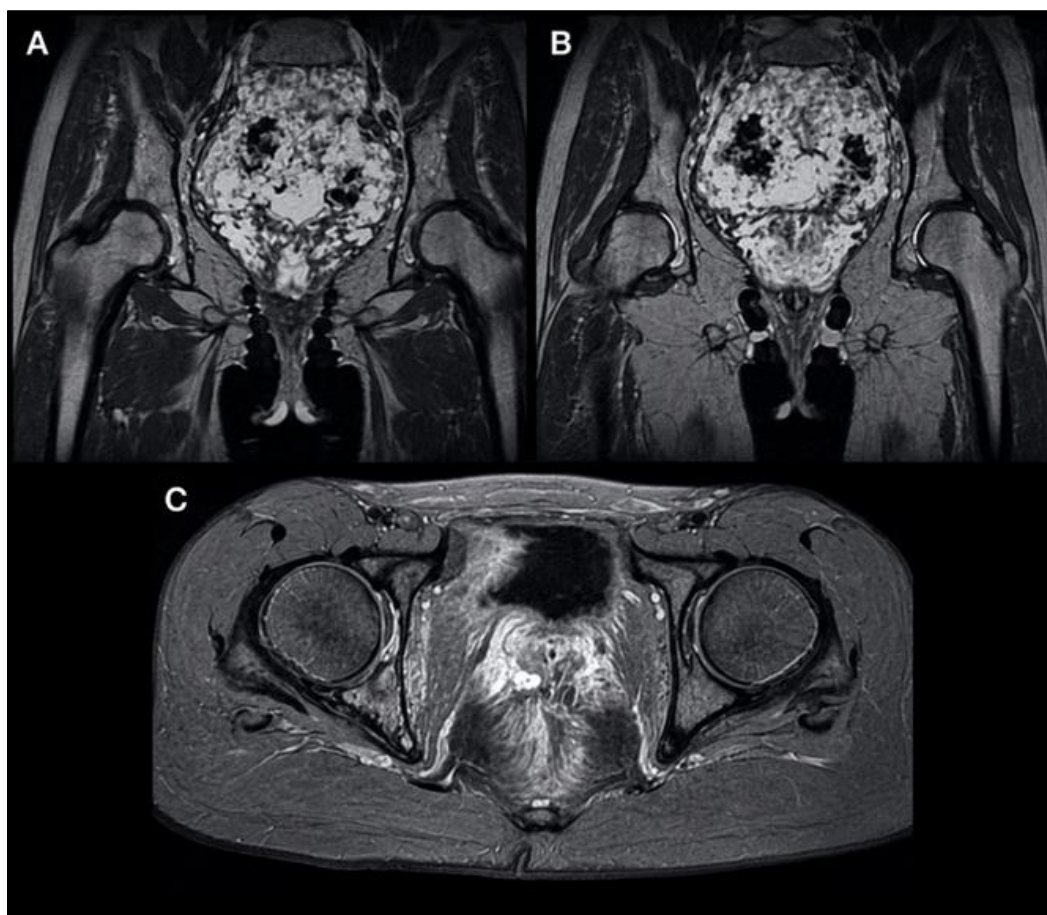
Post-neoadjuvant chemotherapy MRI demonstrating a marked reduction in tumor size and locoregional extension following treatment according to the VDC-IE protocol
